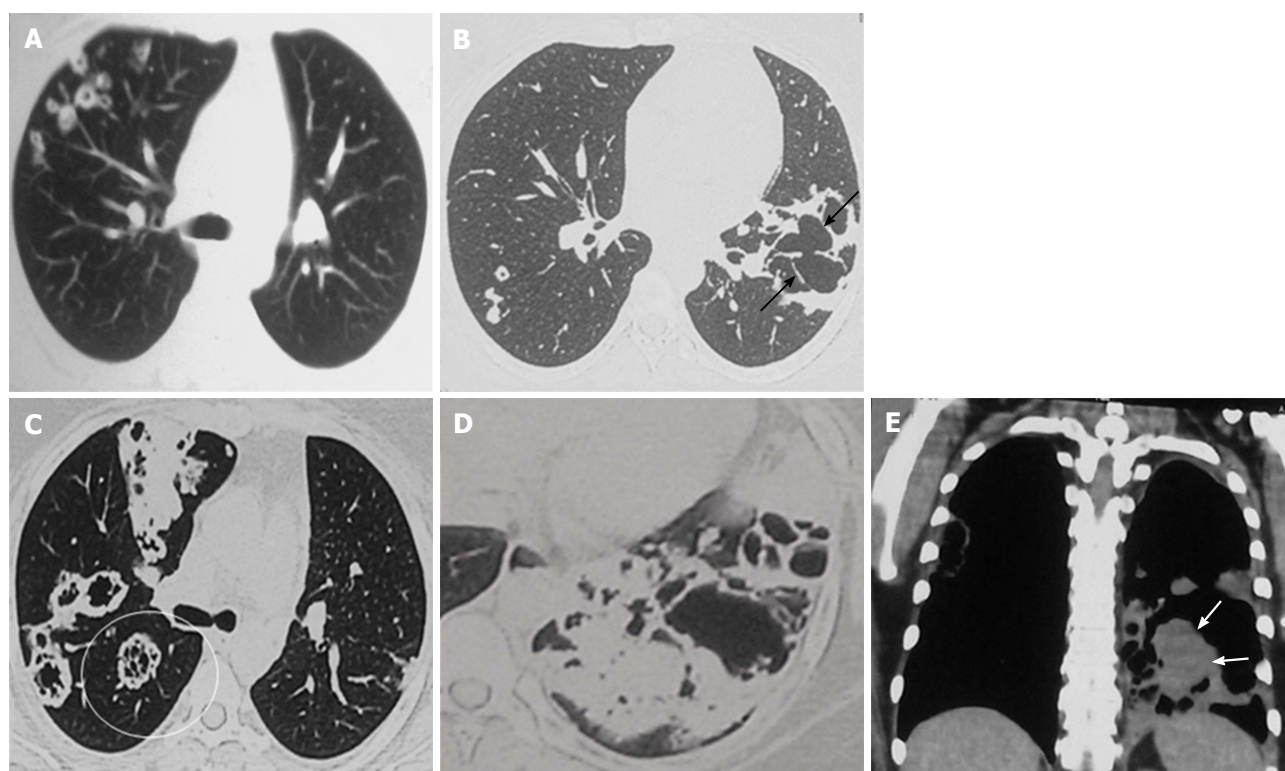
Disease progression with development of soft tissue. Chest CT study of 2012 lung window (A and B) shows multiple new cavitating nodules in RUL (A) and increase in size of LLL cavity with development of internal septations (arrows) (B). No solid nodules or GGO or consolidation is seen. Current CECT images (2014: C to E) demonstrate further increase in size of the lesions and multiple new lesions having internal septations and development of significant soft tissue component in LLL cavity (solid arrows). Also note the "Tambourine" sign in RLL cavities as well (encircled cavity in C). LLL: Left lower lobe; RUL: Right upper lobe; GGO: Ground glass opacity; CECT: Contrast-enhanced computed tomography.
